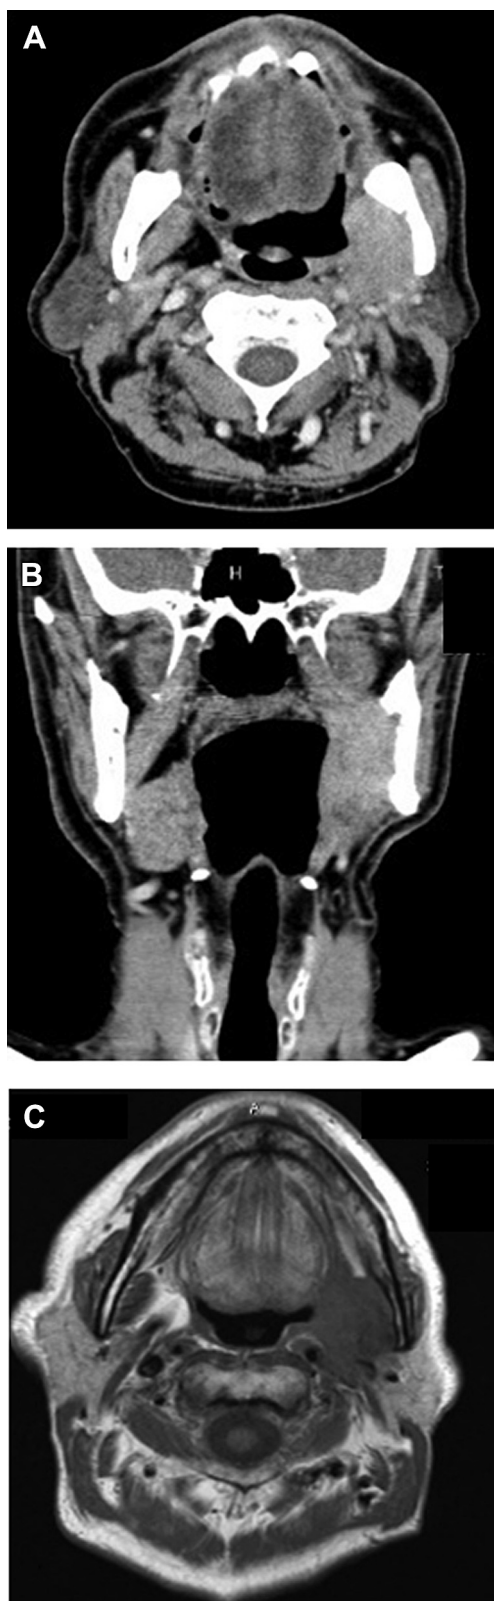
(A) Computed tomography (CT) scan showing a homogeneous enhancing lesion in the left parapharyngeal space extending to the medial pterygoid muscle. (B) Irregular osteolytic cortical bone resorption adjacent to the tumor was
